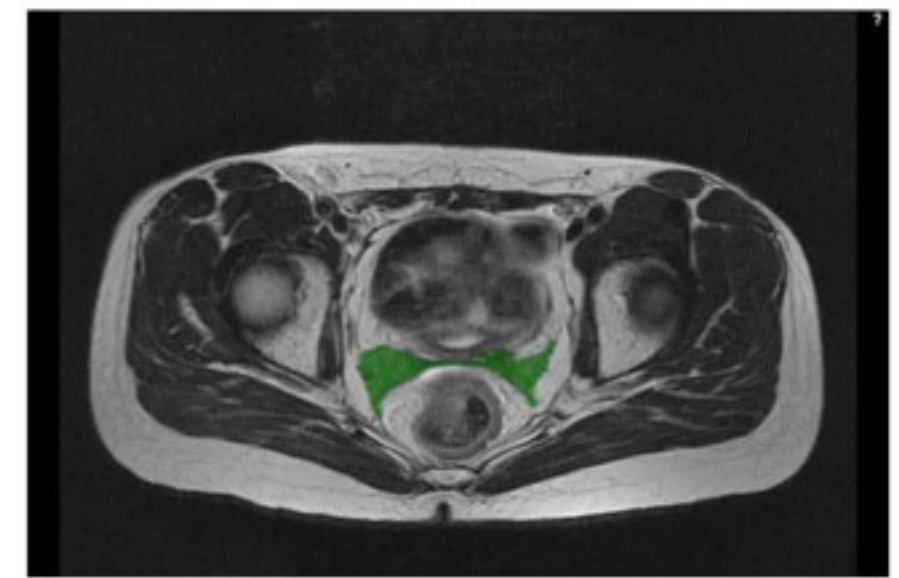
(Color online) Pelvic MRI demonstrating typical remnants of the Müllerian compartment (*highlighted in green*) after conventional radical hysterectomy (Wertheim operation)
